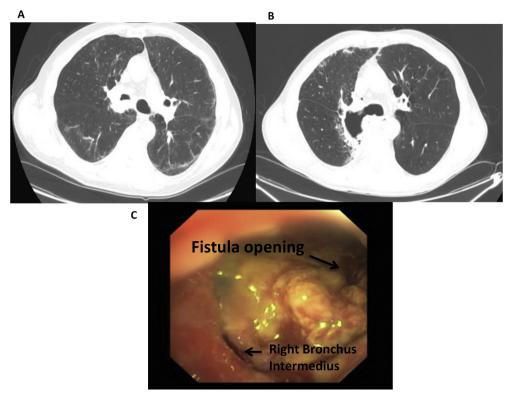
Computed tomography scan of the chest showing a 3.2 × 3.3 cm hilar mass with endo-bronchial extension, narrowing the right main bronchus (A). Computed tomography scan of the chest showing a thick walled cavity in the right upper lobe with tracheo-parenchymal fistula just above the right upper lobe bronchus (B). Bronchoscopy revealed a tracheoparenchymal fistula connecting the right main bronchus to a large cavity in the right upper lobe, destroying majority of the right main bronchus and causing significant attenuation of the bronchus intermedius (C).
